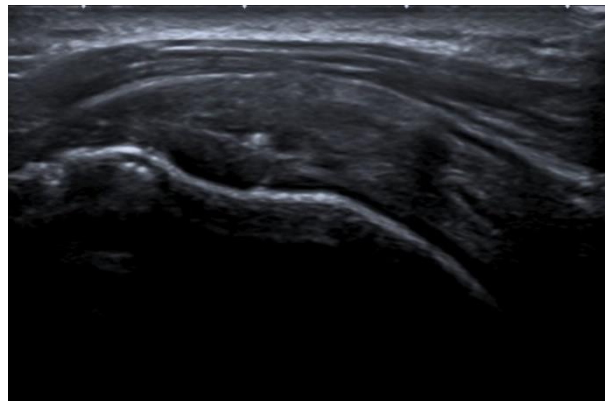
An ultrasound images underwent de-identification.
